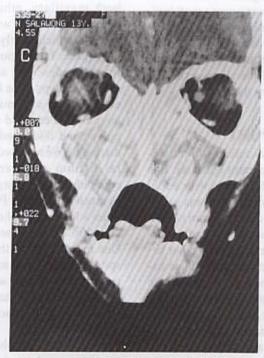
CT scan of the paranasal sinuses revealed polyps fully filled in nasal cavity, maxillary and ethmoid sinuses.
